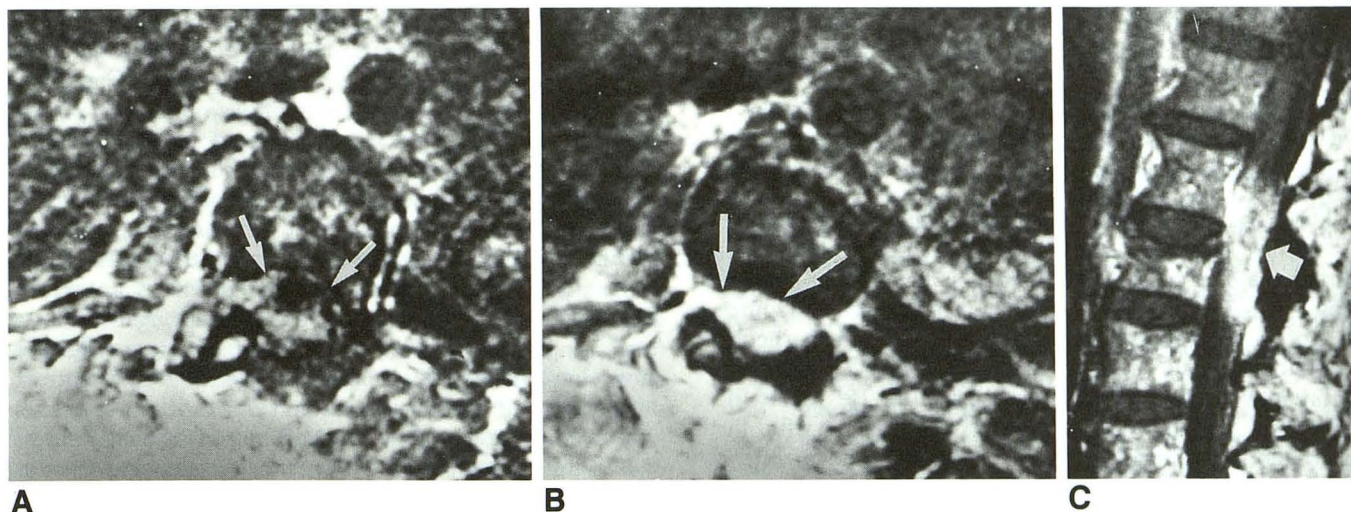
A, Three-millimeter axial T1-weighted image (800/30/2 [repetition time/echo time/excitations], 256 × 256 matrix, 24-cm field of view) shows a mass filling the canal with inhomogeneous increased signal—thought to represent the lymphomatous nerve roots (arrows).
